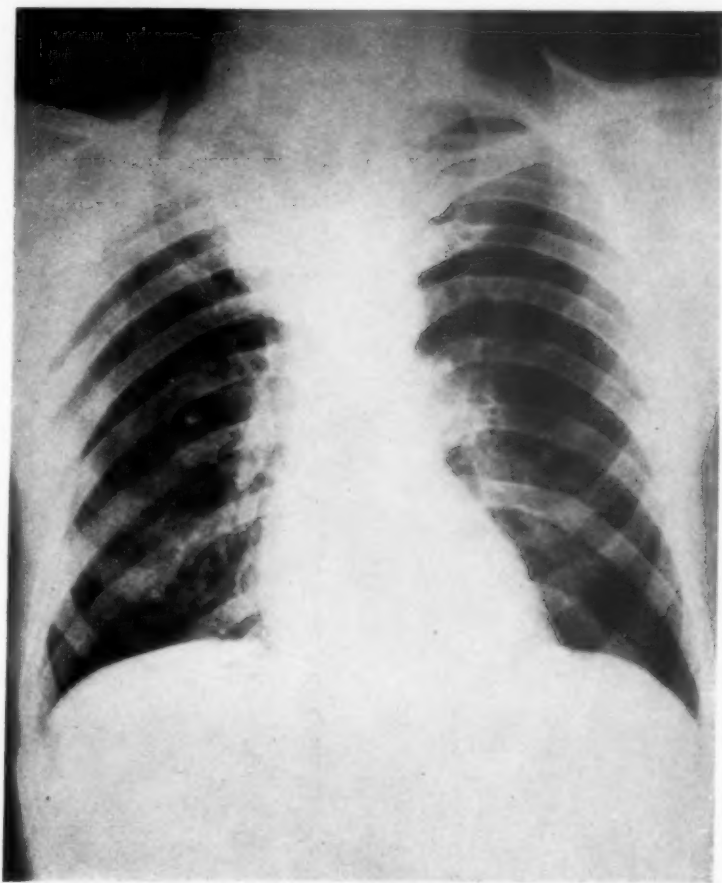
Roentgenogram of chest showing an opacity at the right apex. At autopsy this opacity was found to be due to a non-specific fibrosis. The primary actinomycotic lesion found at autopsy in the right middle lobe is not visualized.
